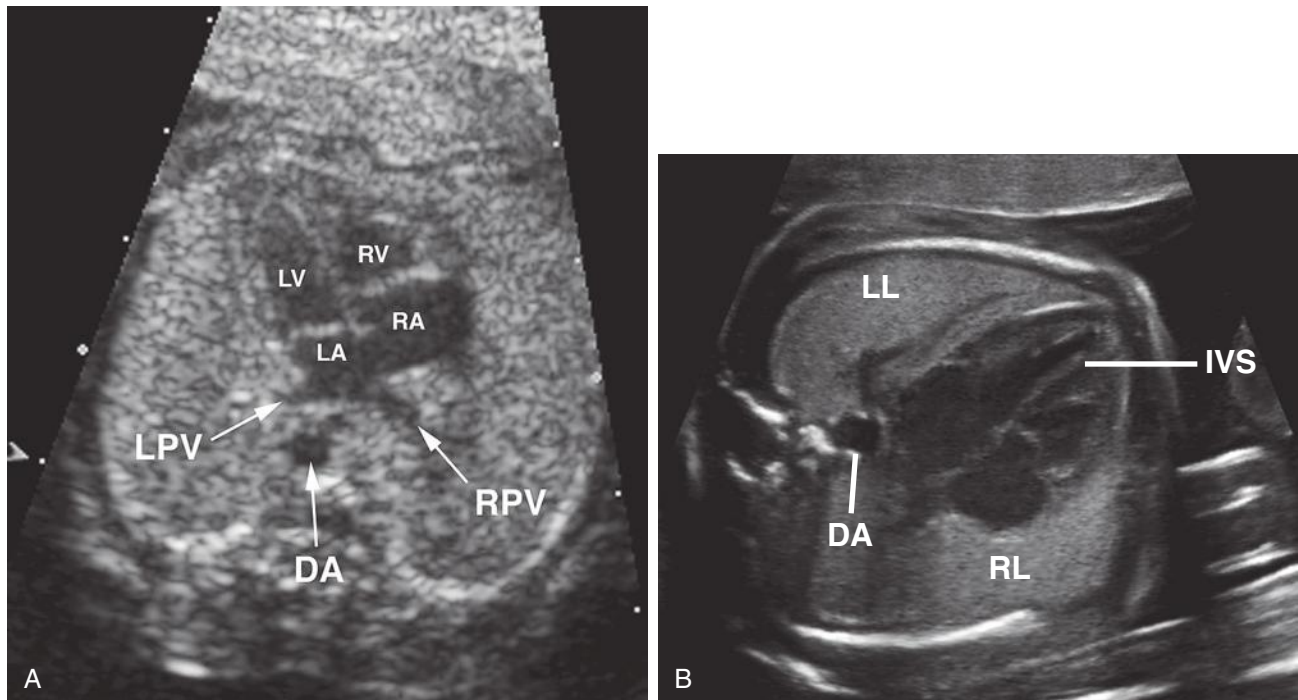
Transverse axial sonograms through the fetal thorax, the "four-chamber view." In A, the fetus is supine. In B, the fetus is in right decubitus position. DA, descending thoracic aorta; IVS, interventricular septum; LA, left atrium; LL, left lung; LPV, left pulmonary vein; LV, left ventricle; RA, right atrium; RL, right lung; RPV, right pulmonary vein; RV, right ventricle.
